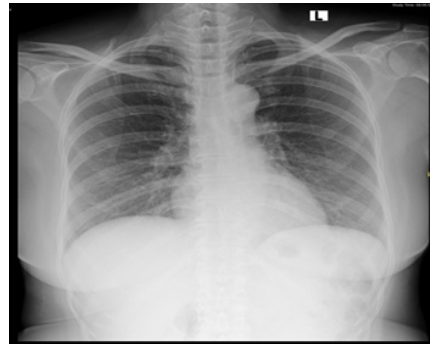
Patient's Chest Radiograph
